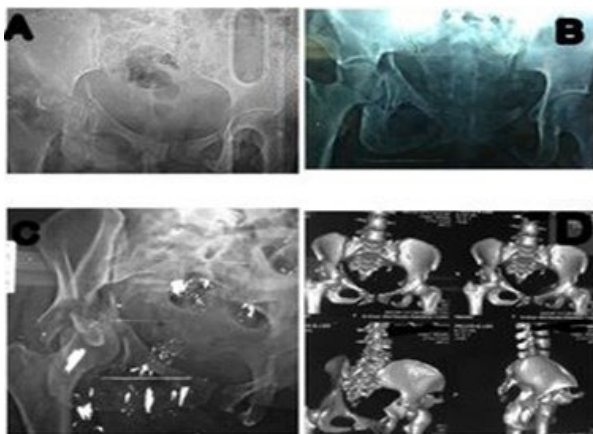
Female, 42 years, MVC with ABC fracture acetabulum and contralateral SI disruption. A, B, C: AP, iliac and obturator views. D) 3D views of CT
